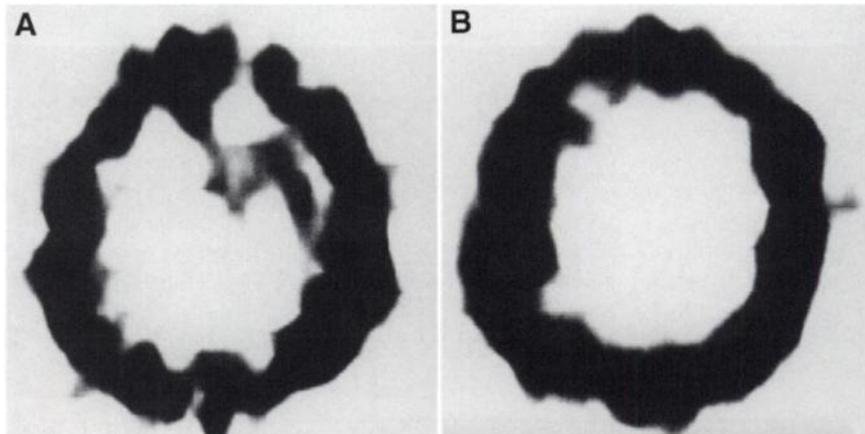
Healthy subject (55-y-old man) with brain SPECT associated with heart imaging. (A) Early SPECT brain image. (B) Delayed SPECT brain image. There is no radioactivity in brain tissue.
